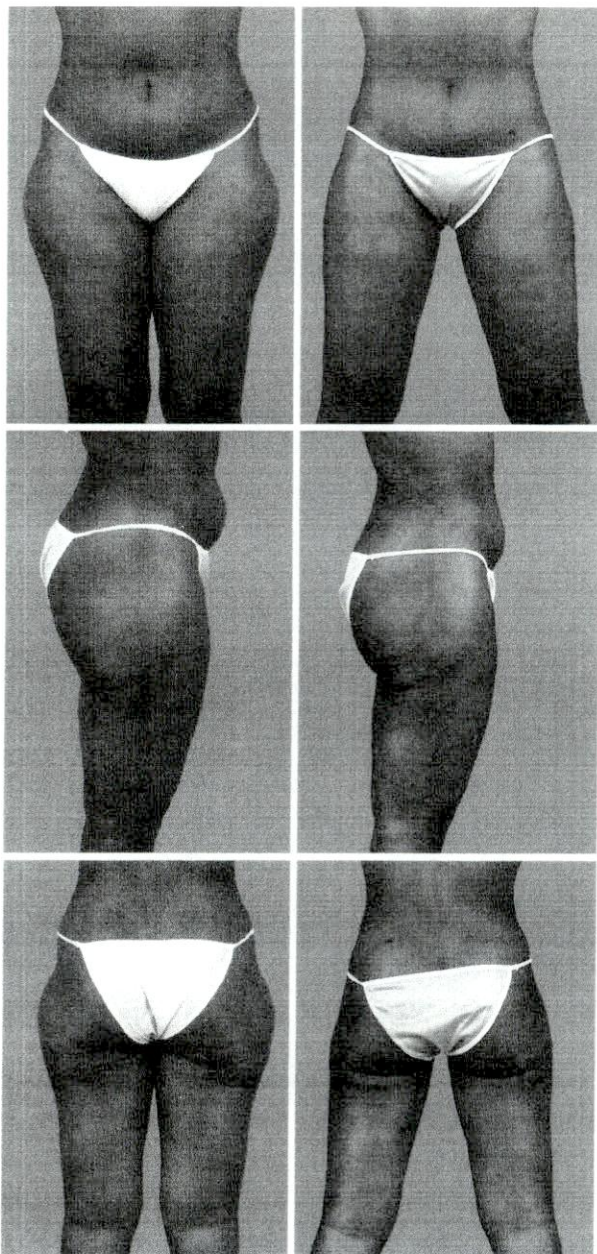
(Left) The patient presented with isolated lipodystrophy of the lower abdomen, hips, and anterior thighs. She underwent circumferential liposculpture with ultrasound-assisted and suction-assisted lipectomy, which resulted in a more natural-appearing silhouette at 3 years postoperatively (right).
